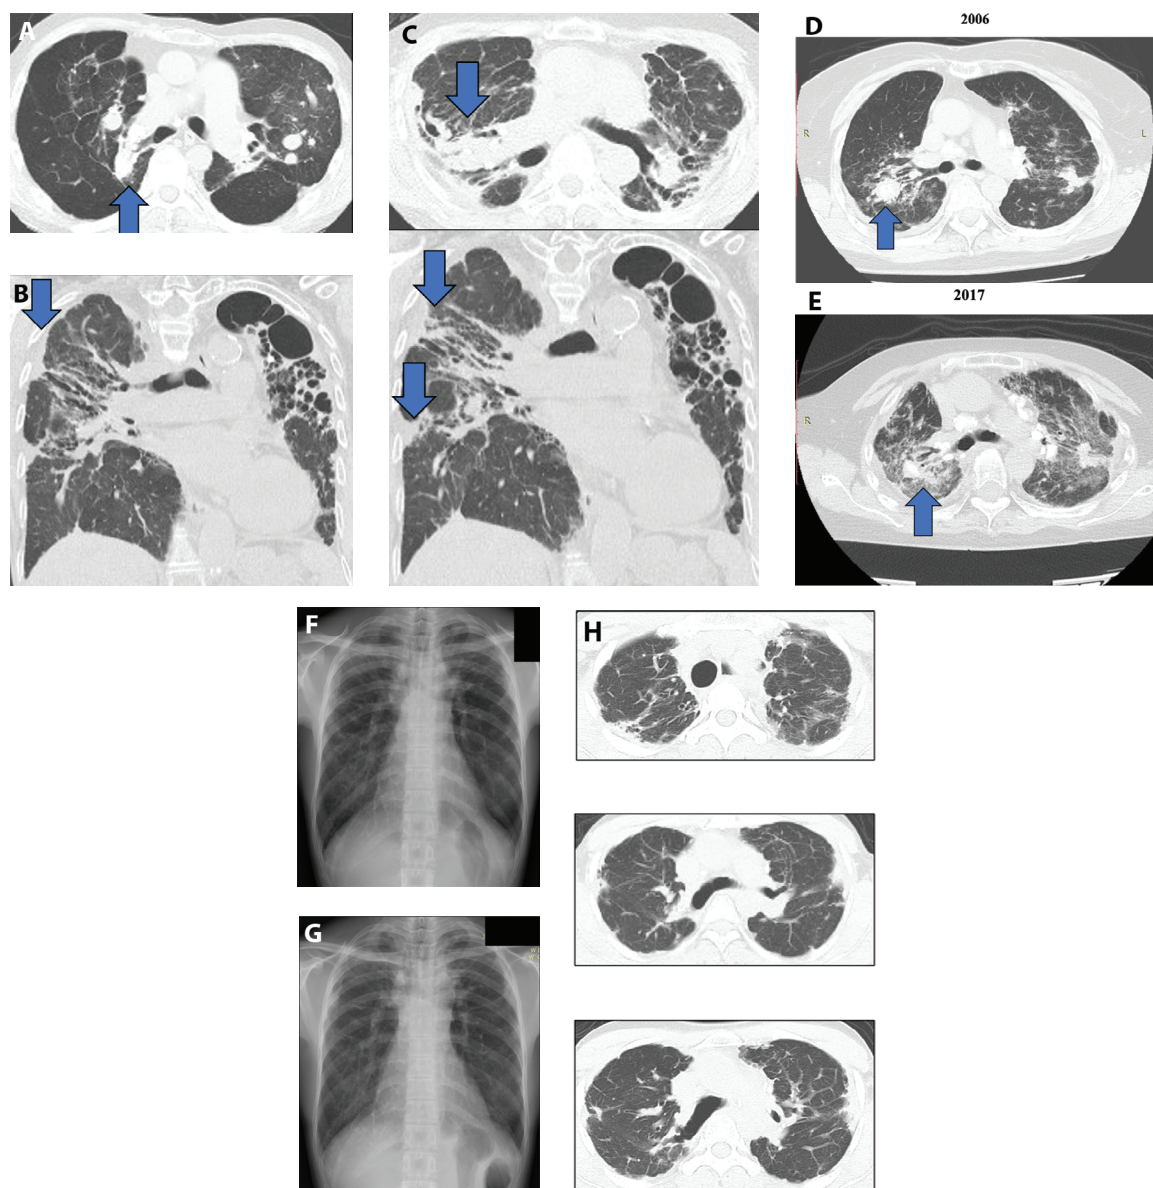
(a-c) Central-peripheral band. Consolidations are defined as areas of homogenous increased attenuation that obscure the pulmonary vasculature. The spatial distributions of abnormalities were designated as *central consolidation* (a), defined as the region from around the trachea to the fifth bronchus, and *peripheral consolidation* (b), defined as the region from the sixth bronchus to the area immediately under the pleura. In addition, we defined areas of consolidations around the bronchovascular bundle that progress toward the mediastinum and pleura as a *central-peripheral band* (c) (7); d, e) Formation process of central consolidation. Pulmonary sarcoidosis is characterized by lesion formation around the bronchovascular bundle (d, arrow). As this lesion develops, the pathogenic agents flow into the bronchial root of the upper lobe, mainly through the centrally directed lymphatic flow, and form a granuloma, which is seen as a mass-like lesion on chest CT (central consolidation) (e). However, these pathogenic agents can also be carried by the lymphatic flow toward the periphery, which results in the formation of a lesion seen as a peripheral consolidation or a PPFE-like lesion on chest CT; f-h) A case with a pleuroparenchymal fibroelastosis-like lesion. In 2007, the patient received a definitive diagnosis of sarcoidosis at the age of 39 years. In September 2008, shrinkage of the upper lobe (SUL) was already noted on chest X-ray (f). Pulmonary function test results showed a force vital capacity (FVC) of 1.71 L (%FVC 64.8%) and a diffusing capacity for carbon monoxide (%DLCO) of 61.5%. In December 2012, chest X-ray (g) and chest CT (h) revealed a wedge-shaped shadow and internal bronchiolar radiolucency, in addition to SUL, which were regarded as a PPFE-like lesion. Pulmonary function test results showed a FVC of 1.60 L (%FVC 62.0%) and a %DLCO of 56.8%.
